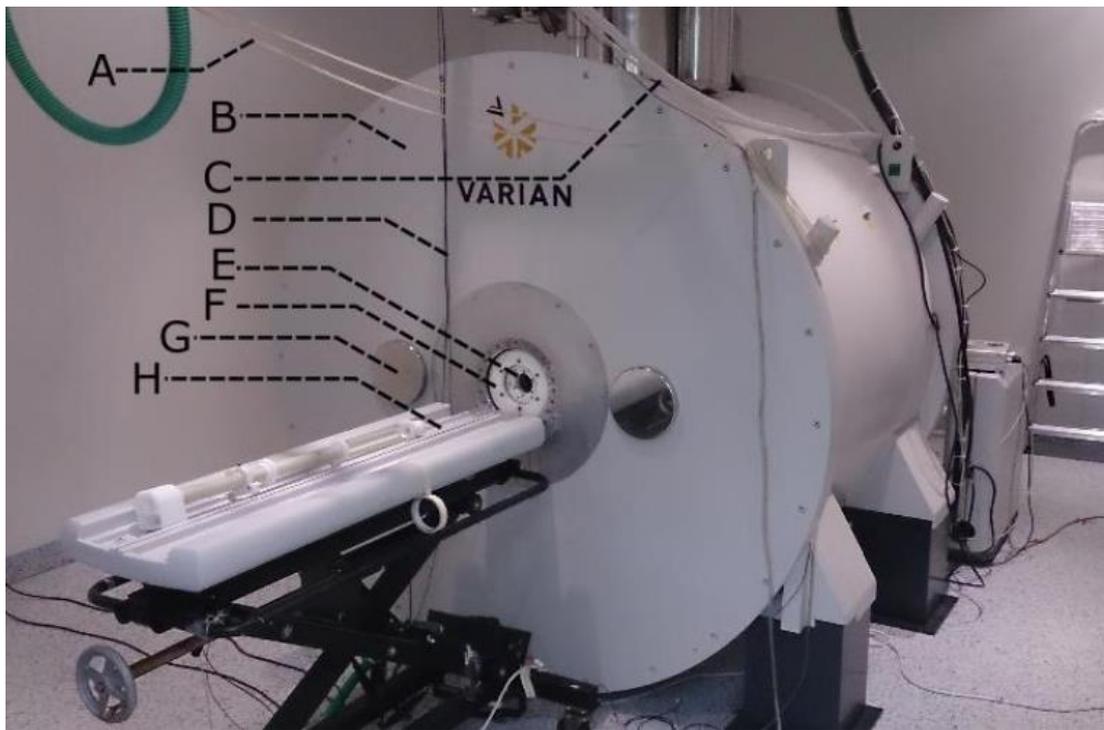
Varian system used for all MRI experiments.
